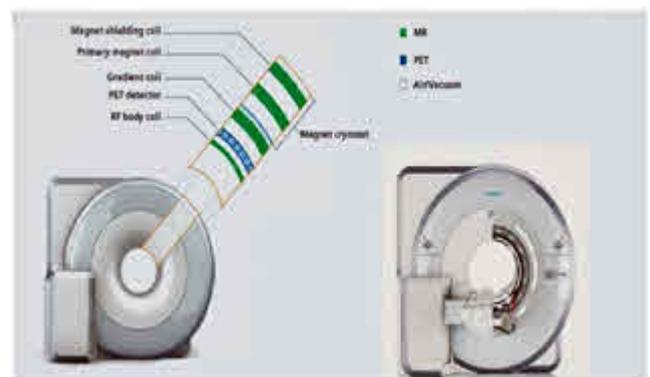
Biograph mMR, a fully integrated, simultaneous whole-body PET-MRI system (courtesy Siemens Healthcare)
